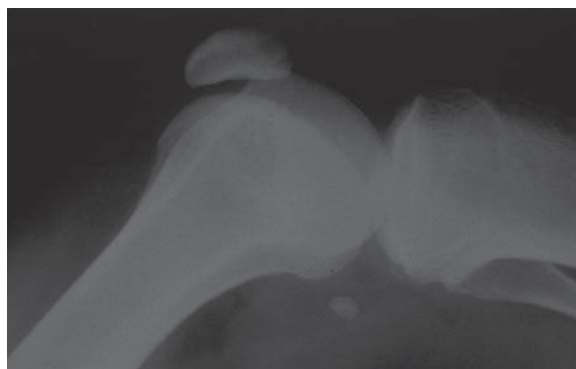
Nail patella syndrome – X-ray showing hypoplasia of the patella.
